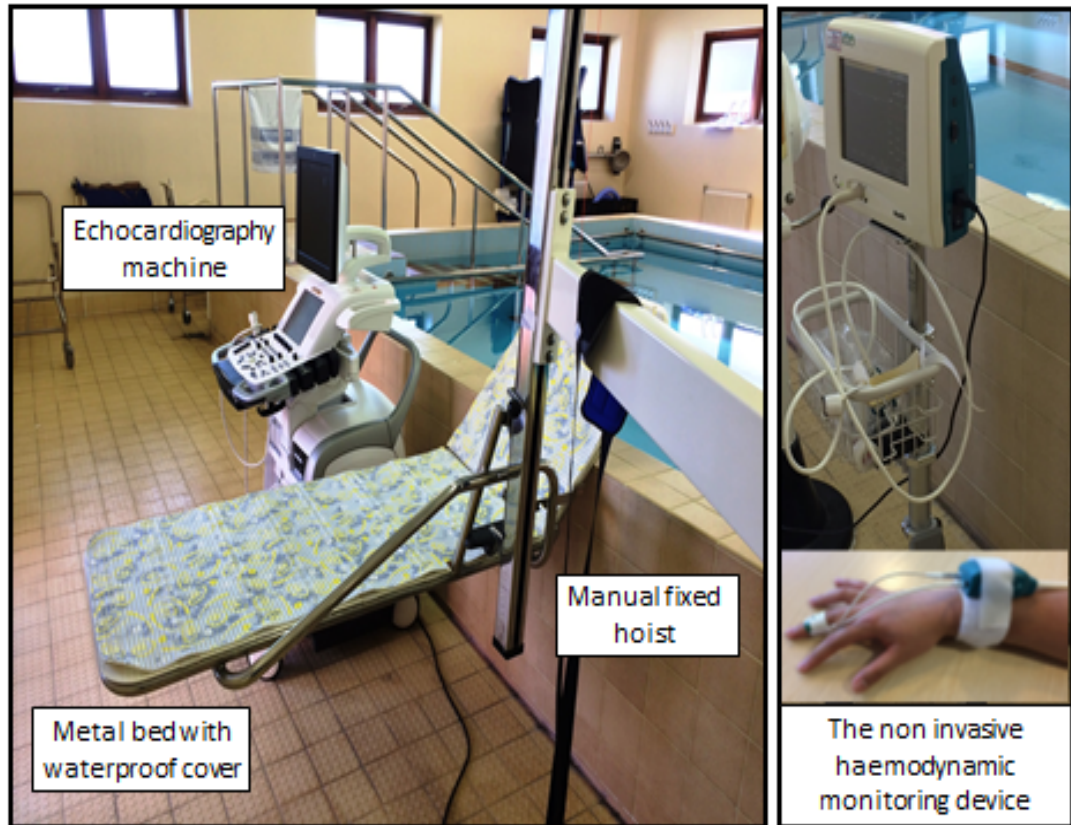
Study equipment. Echocardiography: GE Vivid E9. Non-invasive haemodynamic monitoring device, Nexfin, BMeye
